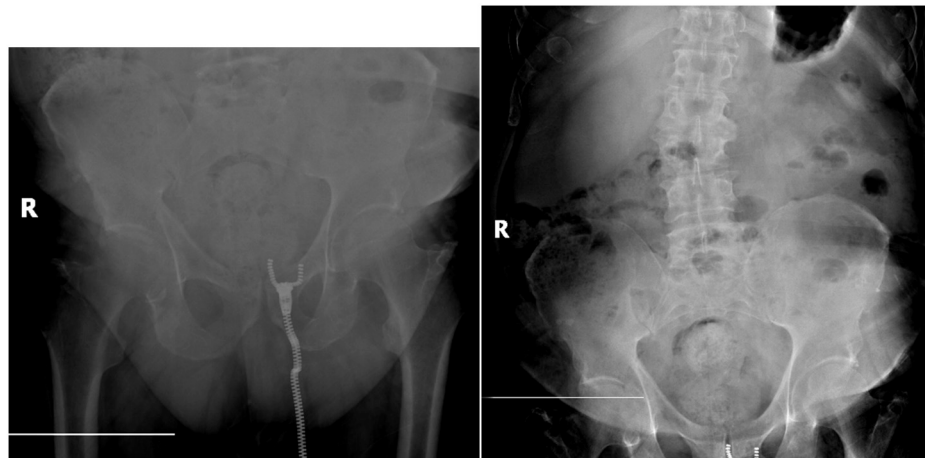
Plain X-ray of the hips obtained at the start of the patient's complaint with no abnormalities.
